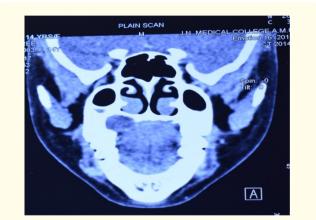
Coronal image of CT Showing Cupped out resorption of underlying bone.
